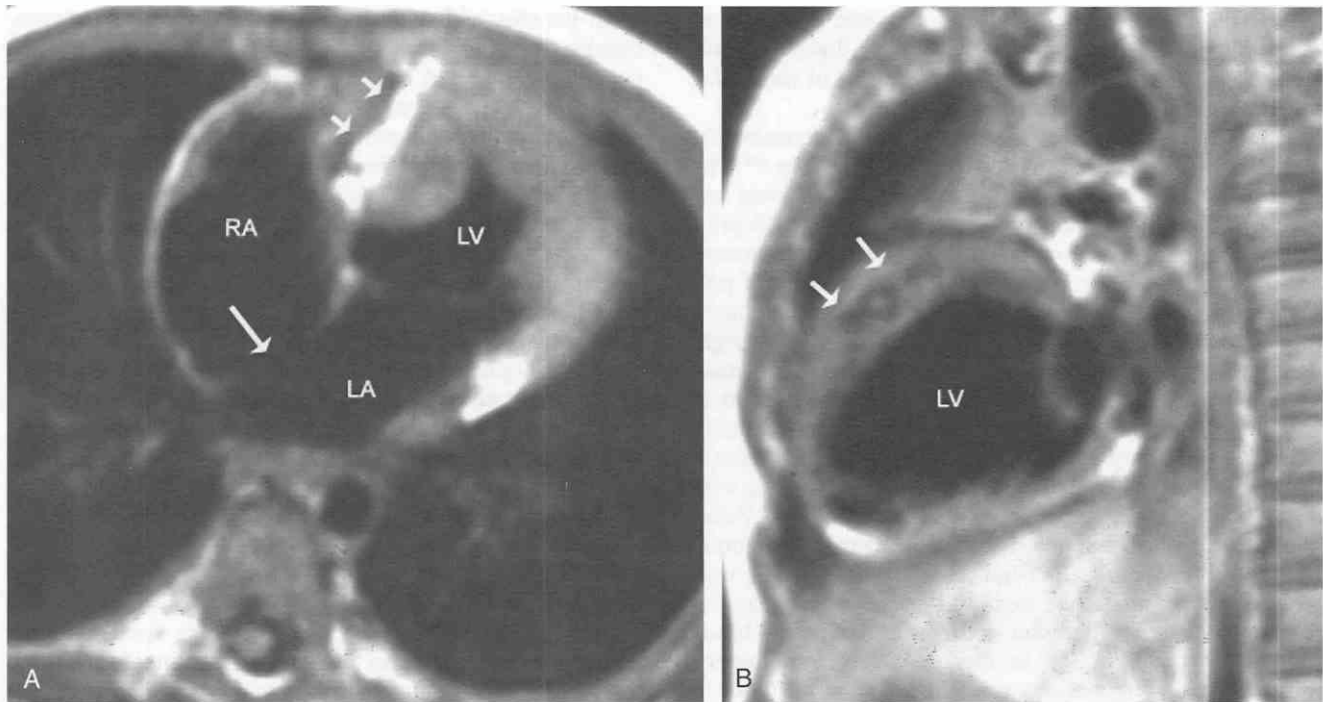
MR image obtained from a 4-year-old boy with tricuspid atresia. *A*, Axial spin-echo acquisition through the anterior atrioventricular ring (*short arrows*) shows fatty replacement in the atretic valve ring. The interatrial communication (*long arrow*) between right atrium (RA) and the left atrium (LA) is broad. Note the severe hypertrophy of the left ventricle (LV). *B*, Sagittal spin-echo acquisition through the interventricular septum. The severely hypoplastic right ventricle (*arrows*) is no more than a slit in the septum. LV, left ventricle.
